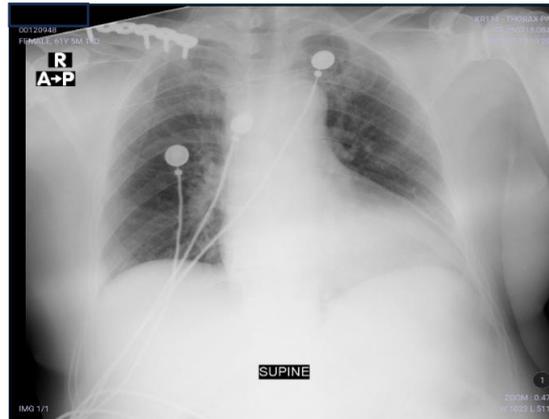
Chest X-Ray, AP view
